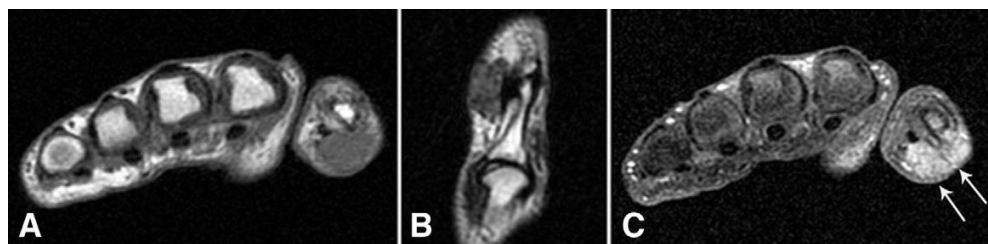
“[...] (A). The mass has a low signal on the sagittal T2W image (B) owing to hemosiderin presence. A significant contrast enhancement of the smooth-contoured mass is observed on the axial fat-saturated T1W image (C) following intravenous gadolinium administration (arrows).” Source: Ergun T, Lakadamyali H, Derincek A, Cagla Tarhan N, Ozturk A. *Magnetic Resonance Imaging in the Visualization of Benign Tumors and Tumor-like Lesions of Hand and Wrist. Current Problems in Diagnostic Radiology.* 2010 Jan 1;39(1):1–16.
